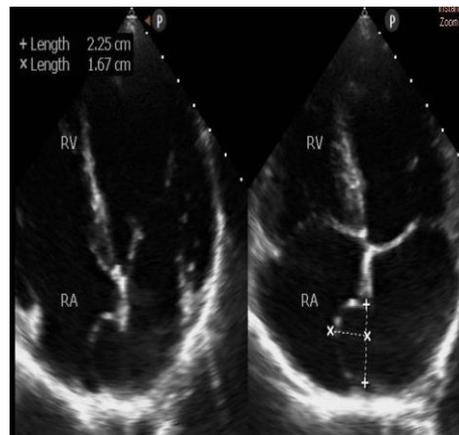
Inverted AP4C view shows Type 1 R ASA. [RA: Right atrium and RV: Right ventricle, AP4C: Apical four chamber]
